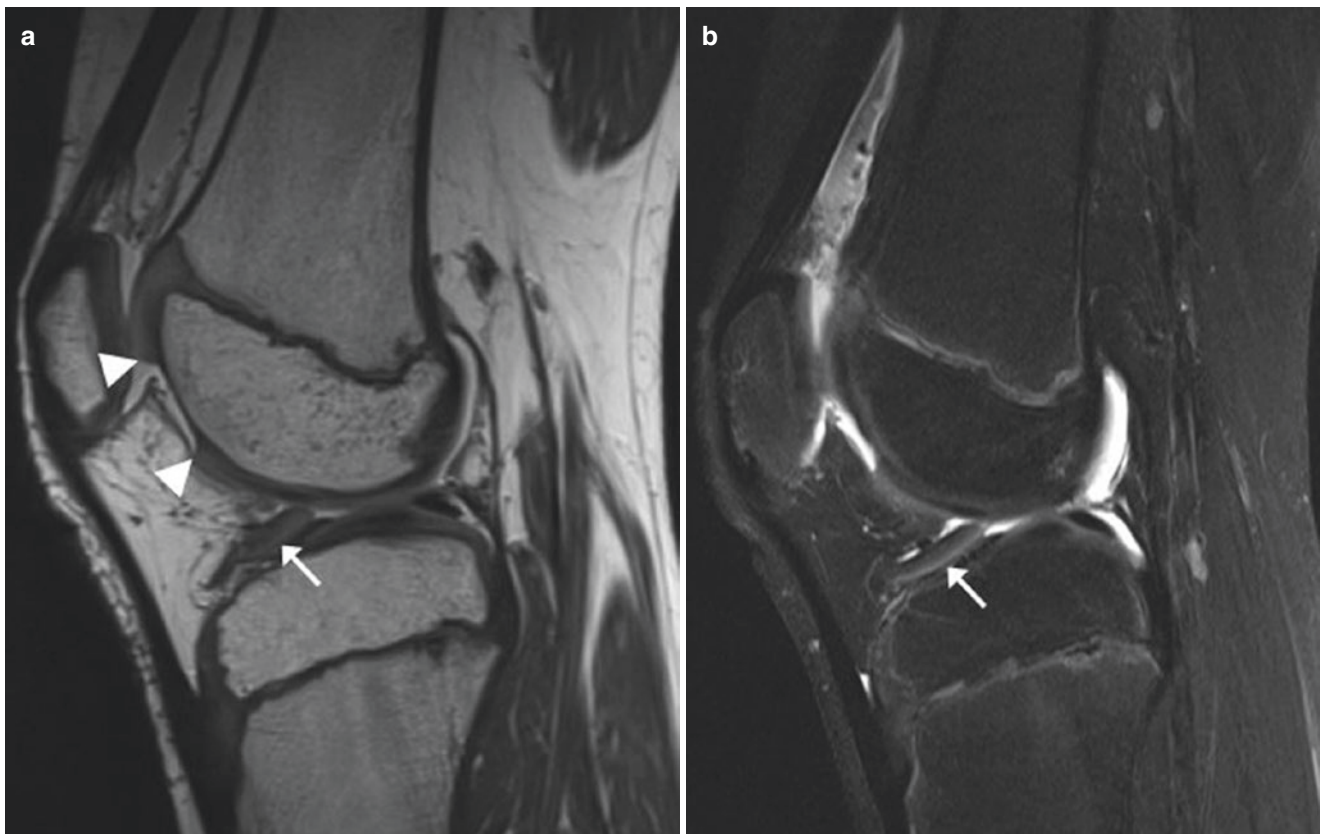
(a, b) Acute osteochondral fracture in an 11-year-old boy who fell onto his knee playing soccer. Sagittal proton density WI (a) and T2-weighted image with fat suppression (b) reveal a large osteochondral defect (margins marked by arrowheads) in the anterior medial
